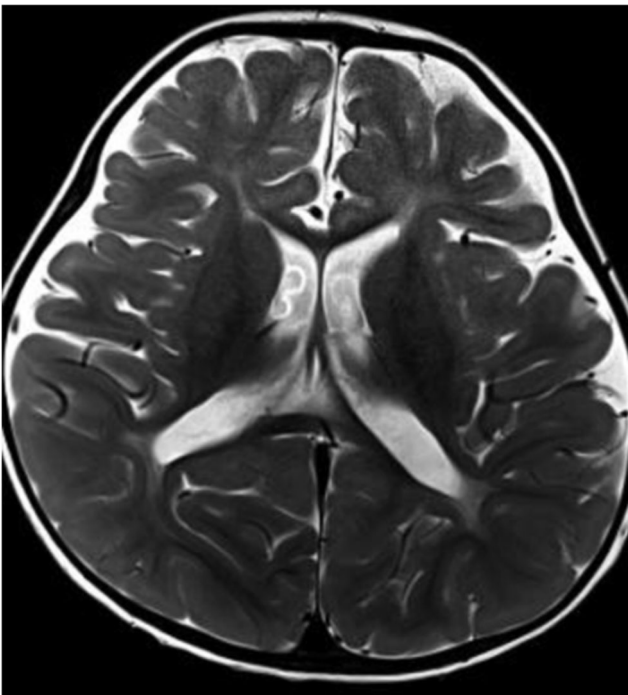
Follow-up MRI revealing volume loss in both cerebral white matters.
